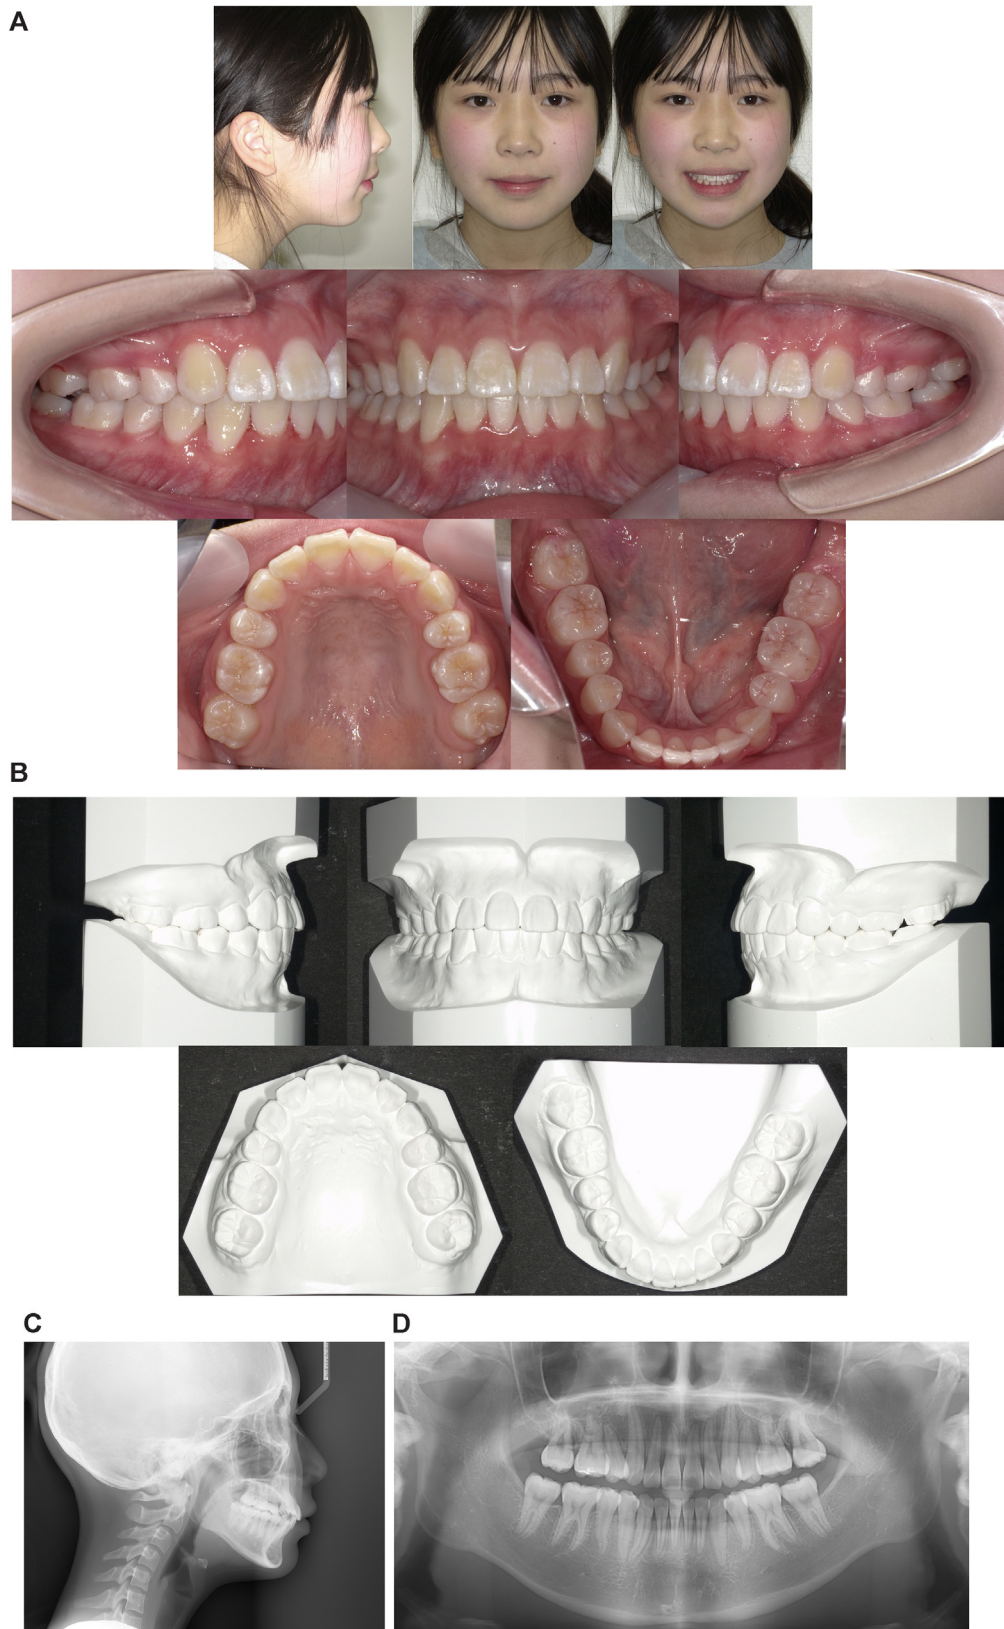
A, Posttreatment facial and intraoral photographs; B, Study models; C, Lateral cephalogram; D, Panoramic radiograph (patient aged 14 years 4 months).
